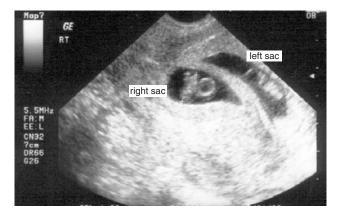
Sonogram demonstrating one viable twin in the right sac and a non-viable twin in the left sac. One week earlier, two viable twins had been seen
